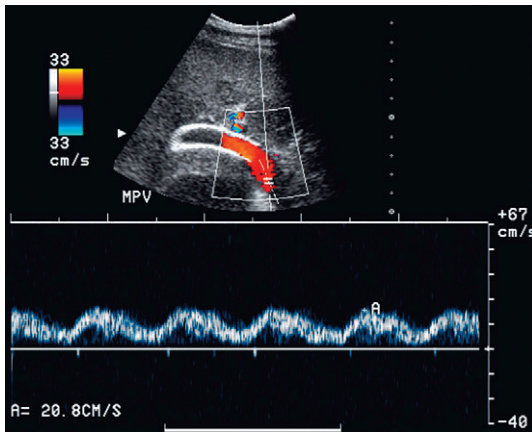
Doppler tracing obtained at the portal vein end of the TIPS. Note the marked periodicity of flow within the TIPS. The waveform is that commonly seen in hepatic veins and inferior vena cava. Identification of this degree of periodicity at the portal vein and of the stent is a confident indicator of a widely patent shunt.
